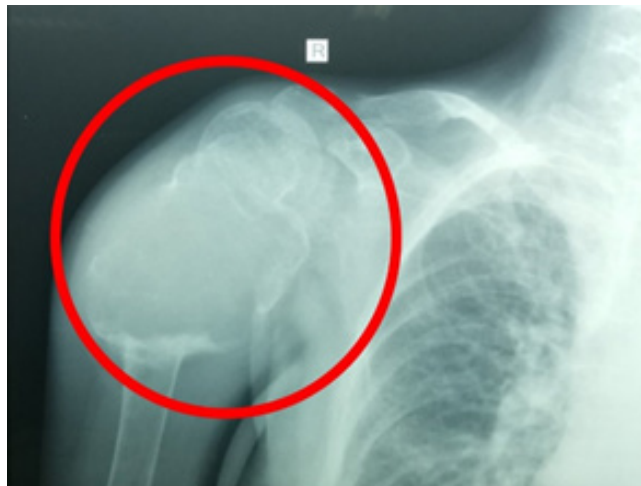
X-ray of right humerus showed a well-circumscribed lytic lesion suspected as a giant cell tumour.
